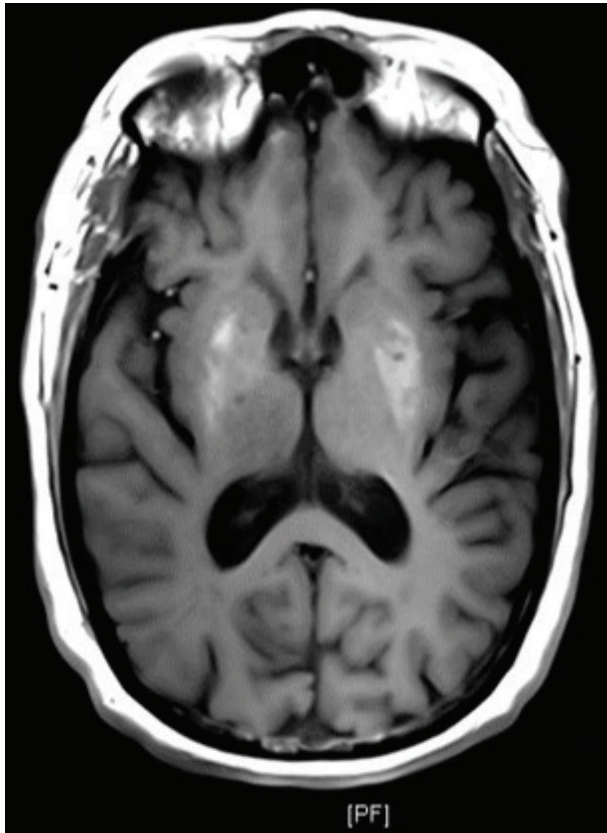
MRI Brain. Axial T1 Image Shows Hyperintensity in the Bilateral Basal Ganglia.
